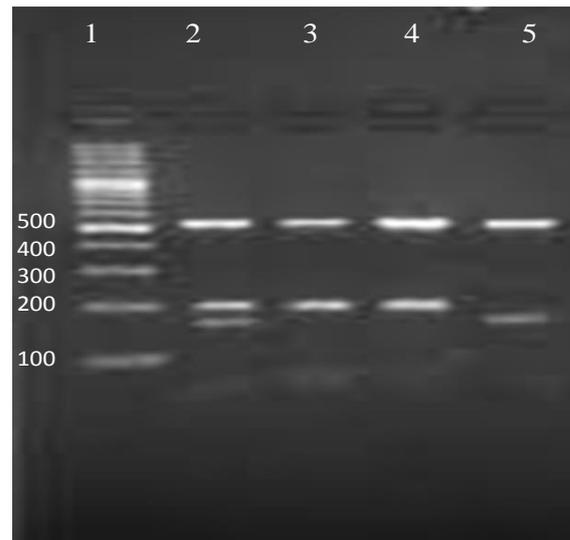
RFLP of the amplified product of rs12979860: lane 1, 100-bp DNA ladder; lane 2, the electrophoresis pattern of genotype CT digested with *Hpy166II* enzyme; lanes 3 and 4, restricted PCR product of genotype CC; lane 5 genotype.
